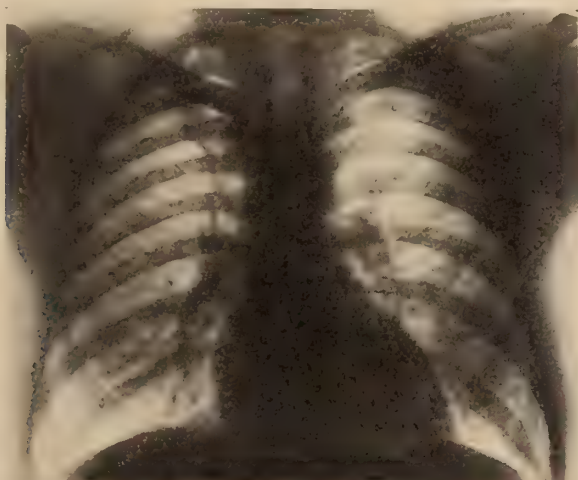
Roentgen examination of the chest two weeks after admission showing complete resolution.
